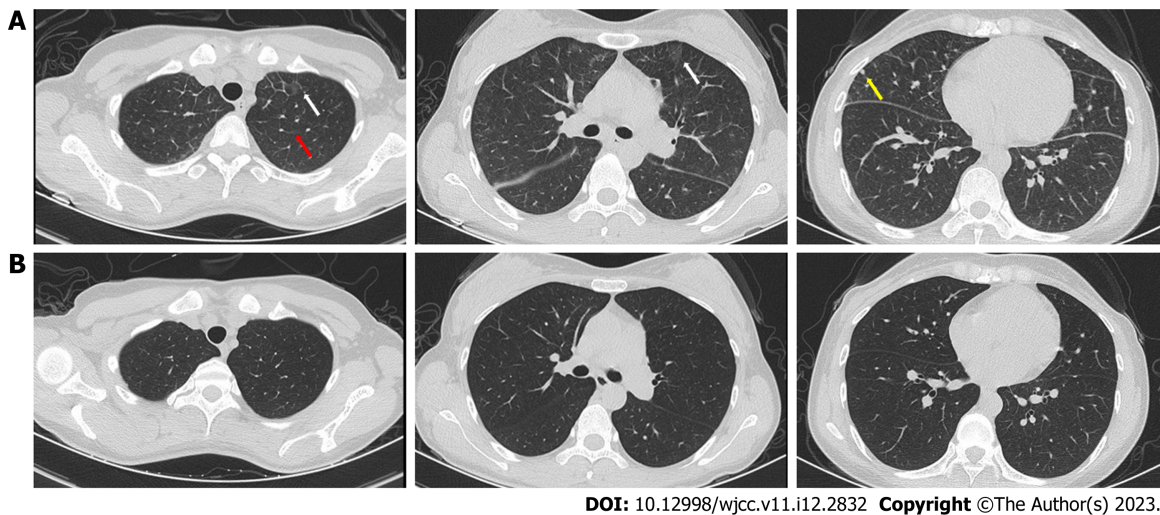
Radiological changes of furazolidone-induced pulmonary toxicity in case 2. A: Bilateral interstitial infiltrates on chest computed tomography (CT) scan on admission. Red arrow indicate interlobular septal thickening. Yellow arrow indicate nodule. White arrows indicate patchy hyperdense foci; B: After treatment, the interstitial infiltrates on chest CT were absorbed.
